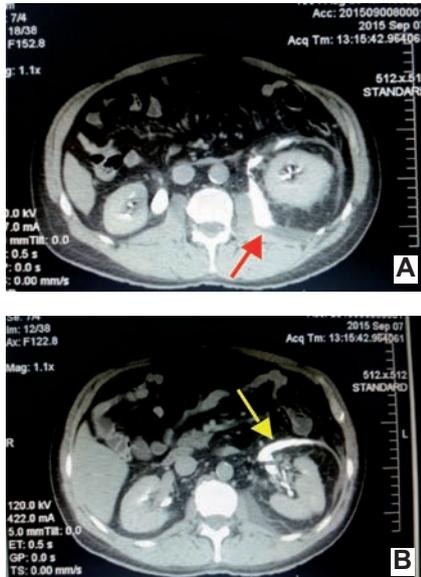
A contrast-enhanced computed tomography scan showing contrast leakage in perirenal and retroperitoneal spaces because of an ulceration of renal pelvis (arrows).
